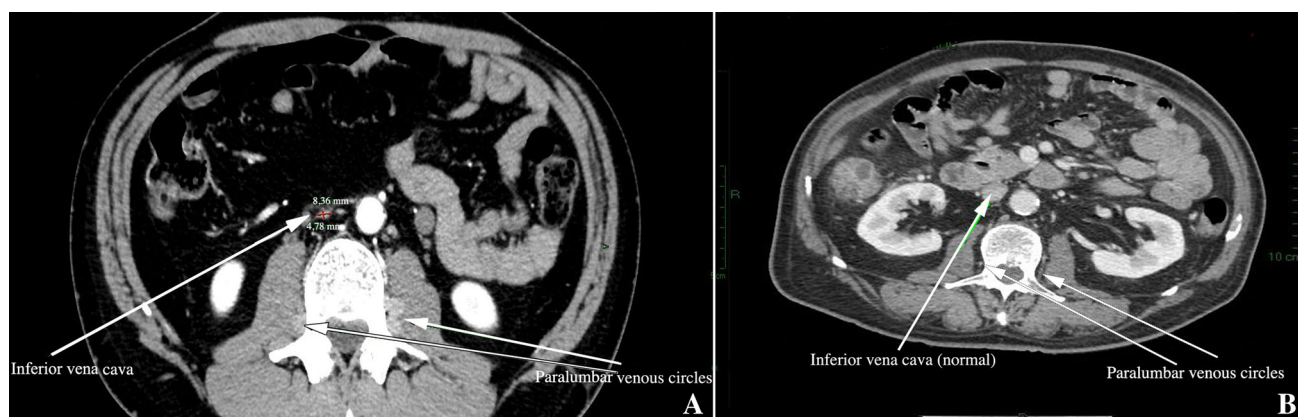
Axial computerised tomography (CT) scans of the abdomen: a in the reported patient shows hypoplasia of the inferior vena cava and marked dilatation of the paralumbar veins (white arrows), b in a normal vena cava of an otherwise healthy 35 year-old man
